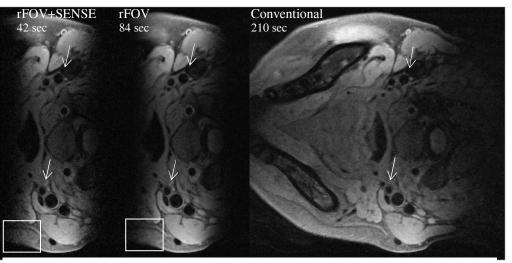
T1-weighted images at the carotid bifurcation. The 3D reduced FOV images with and without SENSE acceleration have comparable quality to images from conventional 2D images.
